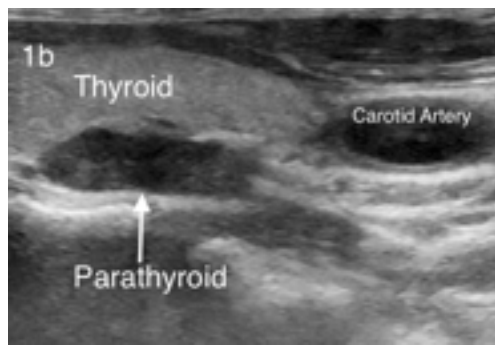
Sagittal images of the ultrasound of the neck.
